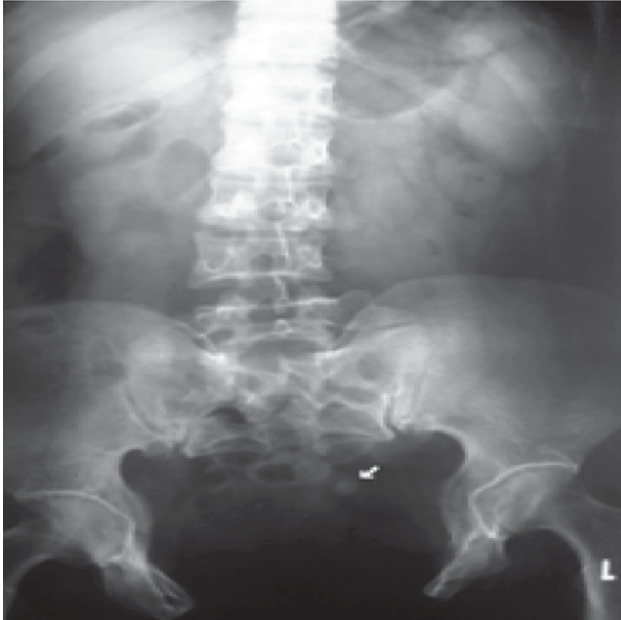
X-ray KUB showing left distal ureteric calculus (arrow) and widely separated pubic bones.
